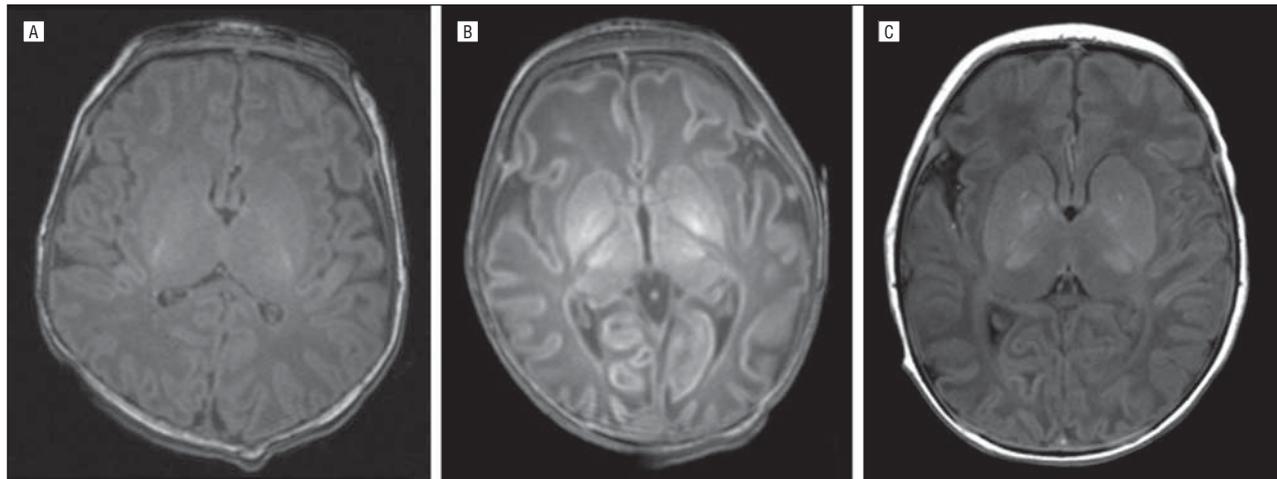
Appearance of hypoxic-ischemic encephalopathy on T1-weighted axial magnetic resonance imaging. A, A normal brain in a term newborn. B, Severely abnormal basal ganglia and thalami (BGT), absent myelination in the posterior limb of the internal capsule (PLIC), and widespread abnormal cortical gray matter. C, Moderately abnormal BGT signal involving the putamen and thalamus, with myelination of the PLIC present.
